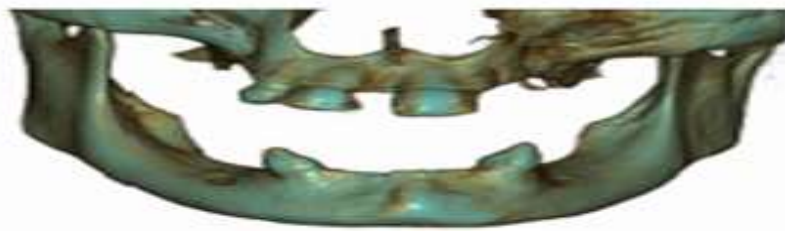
Three-dimensional CBCT image
